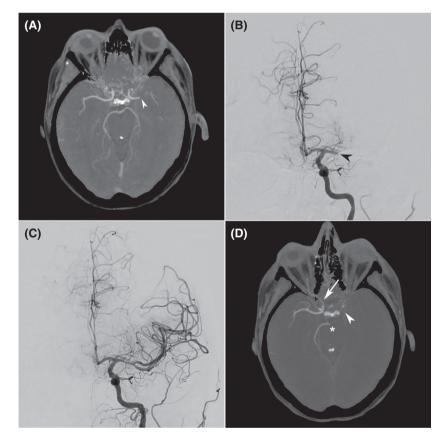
(A) Initial CT angiography 1.5 hours after onset of right hemiplegia, demonstrating left middle cerebral artery occlusion (arrowhead). Angiography before (B) and after (C) endovascular thrombectomy was performed with complete recanalization 3 h and 15 min after symptom onset. (D) Nine hours after thrombectomy, the patient failed to regain consciousness and had bilateral fixed mydriasis. CT angiography demonstrated multiple new arterial occlusions: left internal carotid and middle cerebral arteries (arrowhead), right cervical and cavernous internal carotid artery (artery (arrow), and distal basilar trunk and left posterior cerebral artery (asterisk).
